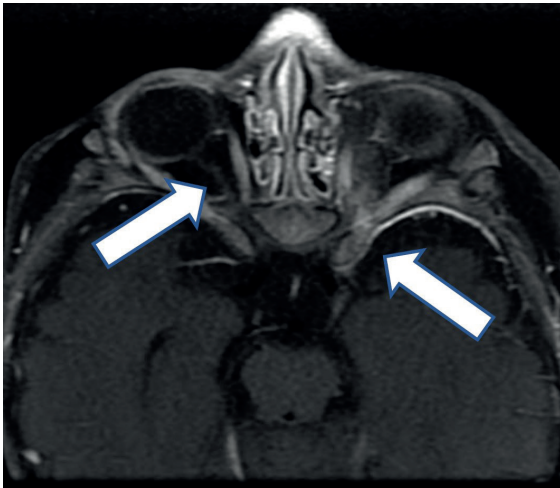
Axial contrast enhancing T1W MRI shows asymmetric contrast enhancement at the left orbital apex, thinning of the optic nerve.
